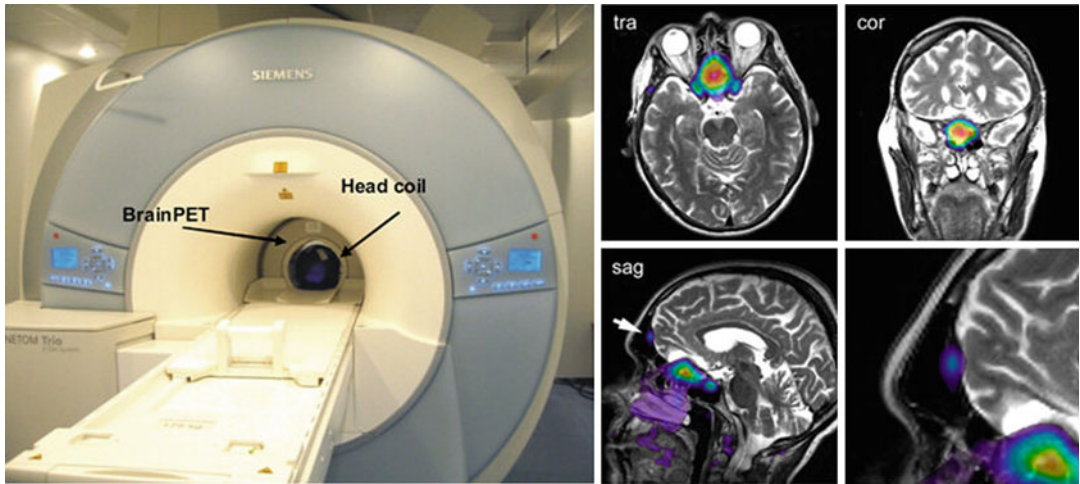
APD PET inserts for brain PET/MRI (Reprinted from [39] and [1] with permission)
